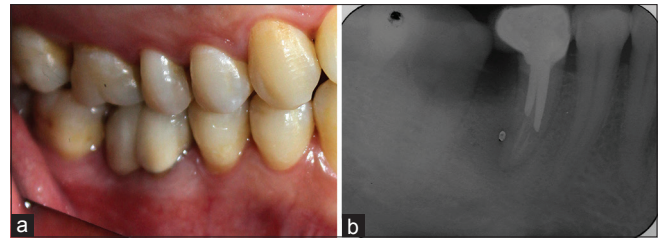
Final restoration after 18 months. (a) Intraoral view, (b) periapical radiograph
